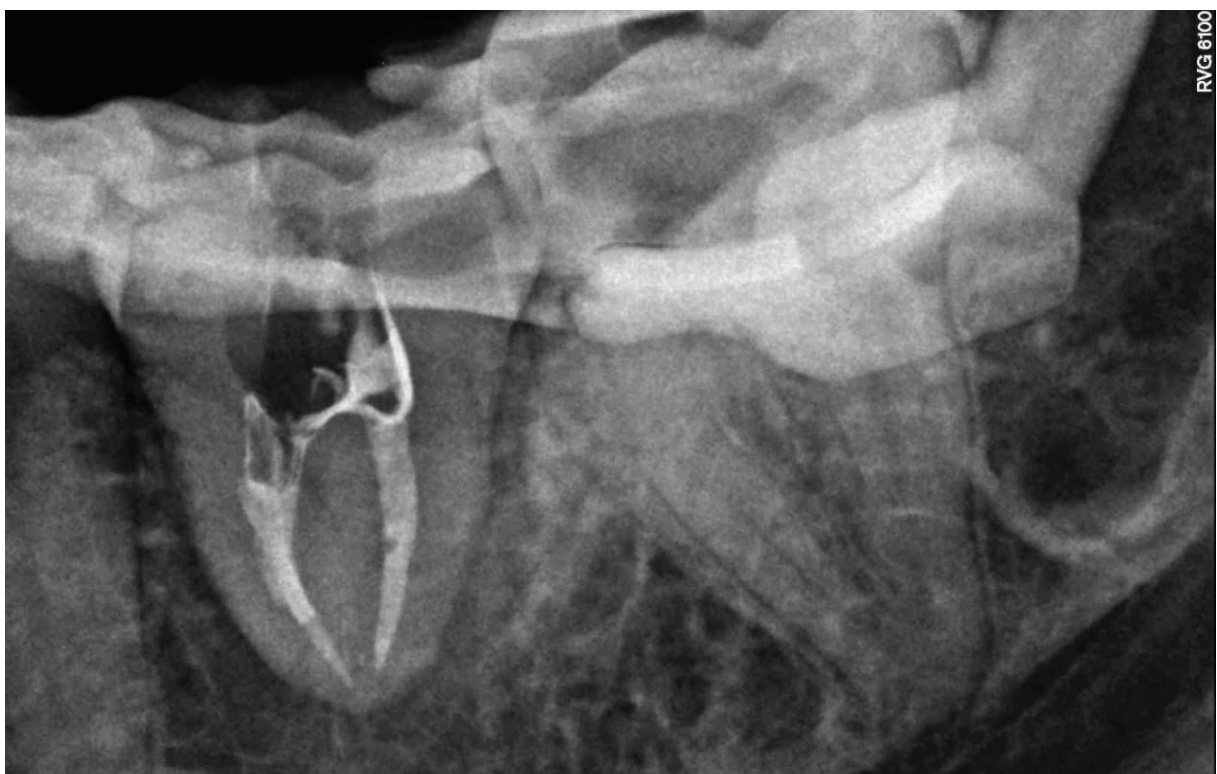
Periapical X-ray after root canal filling with warm gutta-percha.
